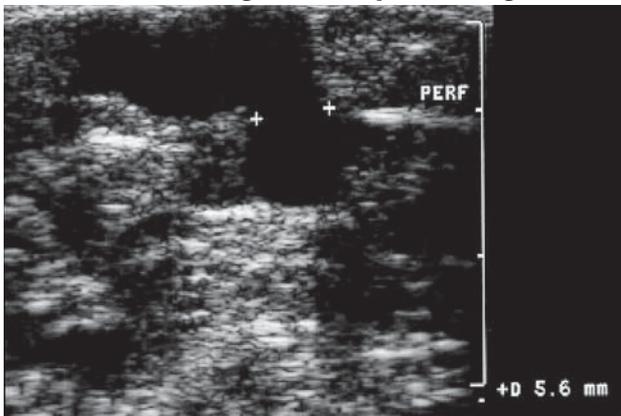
B-mode ultrasound image showing a large incompetent calf perforator, coursing through the superficial fascia to the deep veins
